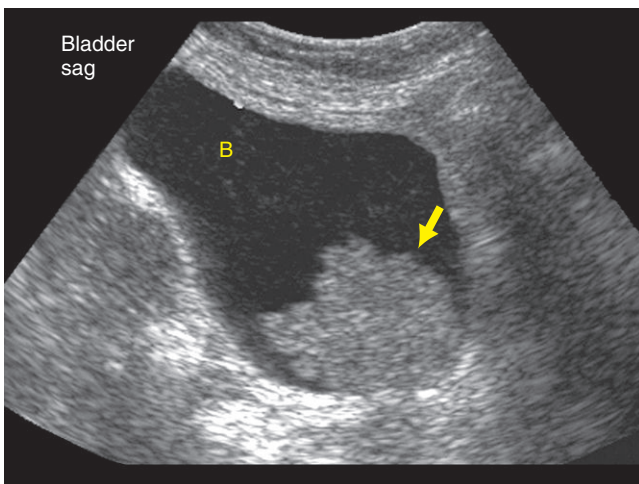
Longitudinal ultrasound of the bladder (B) demonstrating echogenic mass (arrow).
